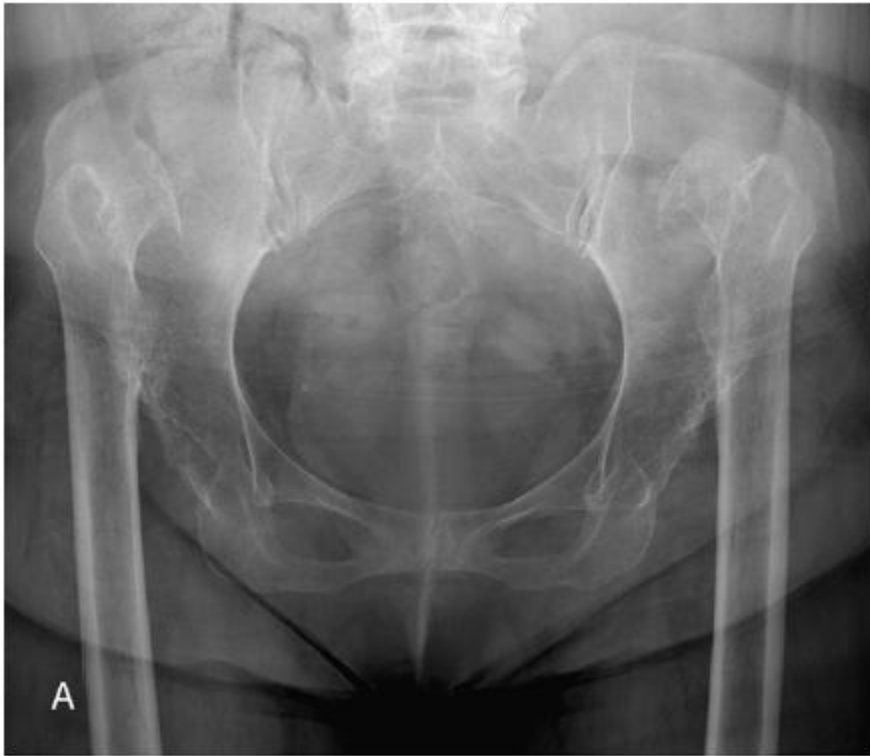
A 70-year-old woman with bilateral severe dislocated hip. Preoperative (A) and postoperative (B) anteroposterior radiographs at 8- (right) and 7-month (left) follow-up.
